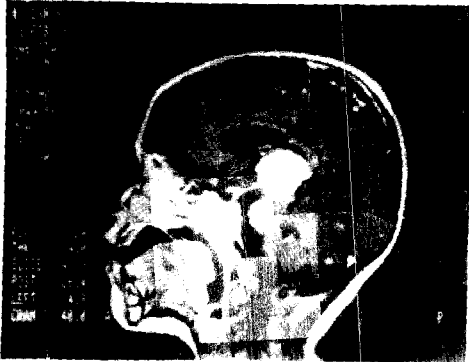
MRI, T1 weighted image with Gd-DTPA showing an enhancing S. O. L. in the pineal region which proved to be a pineoblastoma.
